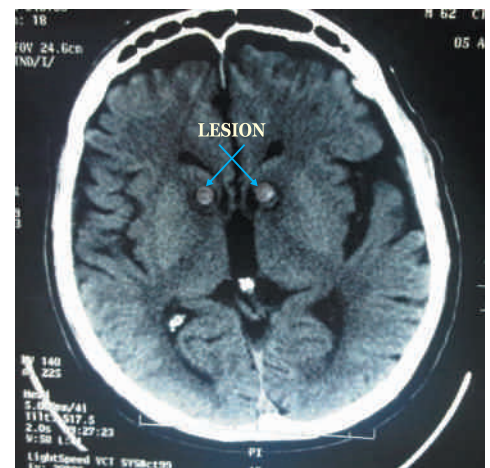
Postoperative axial CT Scan showing bilateral anterior capsulotomy
